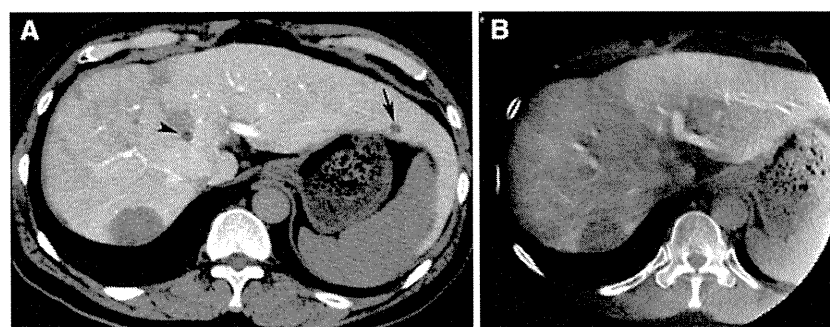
A 56-year-old man with multiple HCC. A Conventional CTAP image shows a large tumor in the right lobe of the liver and small tumor in the left lobe of the liver (*arrow*). A small cyst is also seen in the left lobe of the liver (*arrowhead*). B CBCTAP image depicts the large tumor, but the small tumor is outside of FOV. The small cyst in the left lobe of the liver was depicted in another image (not shown).
